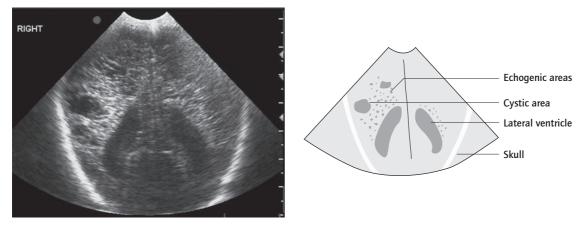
Postnatal ultrasound of cystic periventricular leukomalacia, a precursor to cerebral palsy.
